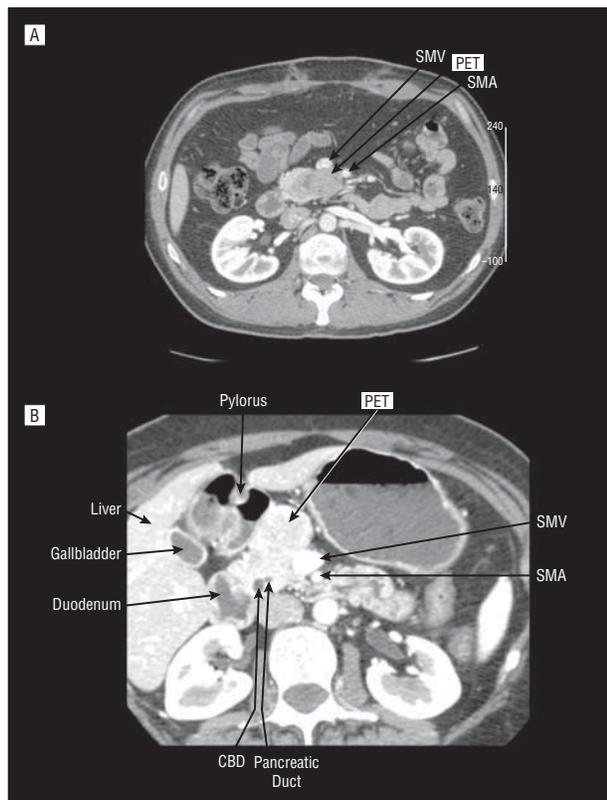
Computed tomography scans of 2 patients with pancreatic endocrine tumor (PET) in the head of the pancreas abutting the mesenteric vessels. A, The PET is in the uncinate portion of the pancreatic head and lies abutting the posterior surface of the superior mesenteric vein (SMV) and superior mesenteric artery (SMA); B, The PET is in the anterior portion of the head of the pancreas abutting the anterior and lateral wall of the SMV. These patients could have the PET dissected off the SMV. CBD indicates common bile duct.
